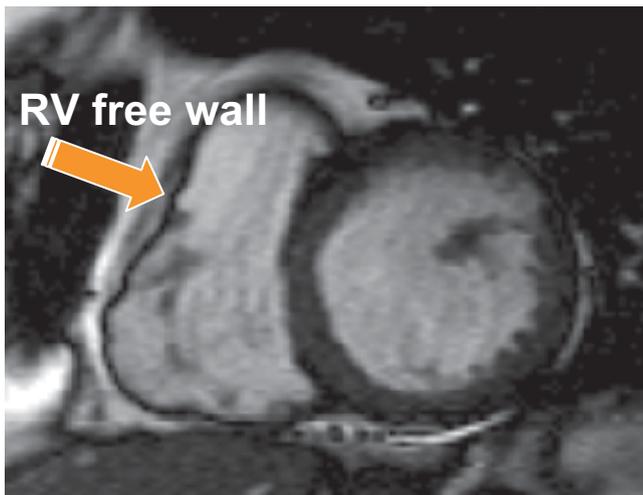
Cardiac magnetic resonance imaging from a patient with ARVC/D. Note the clarity of the thinned RV free wall (arrow) and the dilation of the RV cavity
